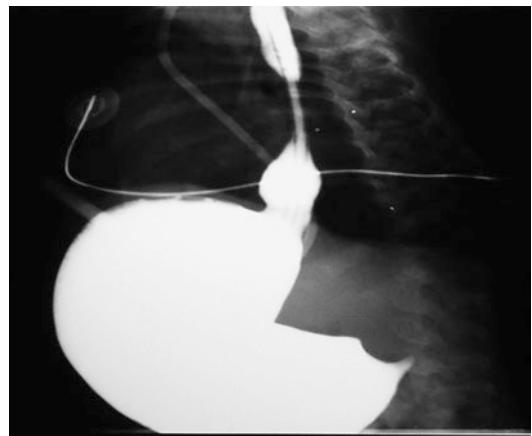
UGI tract film in newborn with HPS. Radiographic oblique view shows a large distended stomach, filled from barium, and delayed gastric emptying. Gastroesophageal reflux is associated
